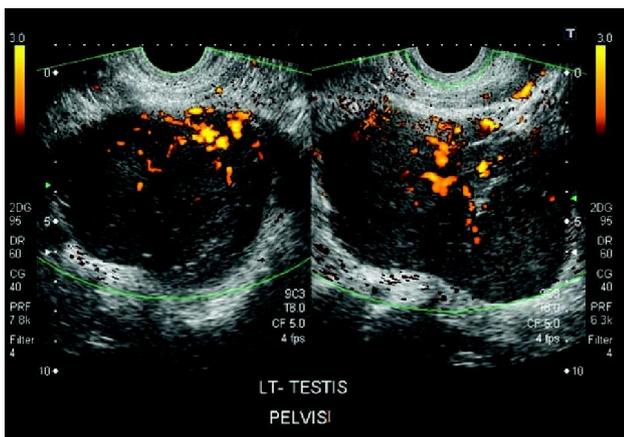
Color Doppler showing increased flow in left testis.
